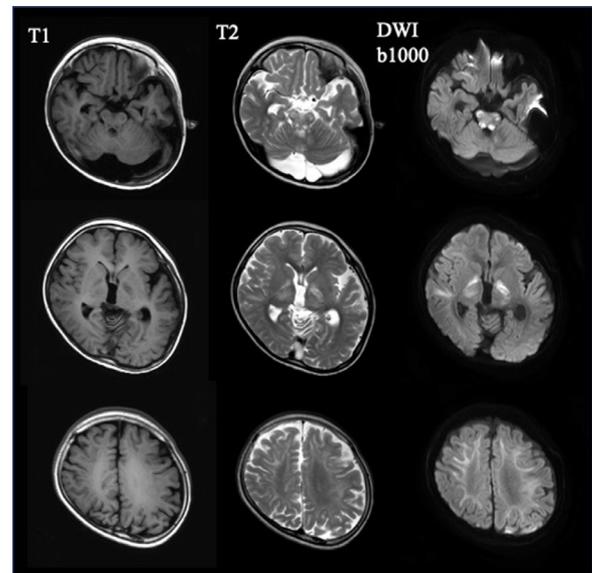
MRI at the age of 7 showed symmetric hypointensity on T1- (left column), and hyperintensity on T2- (middle column) and diffusion-weighted (right column) images in the subcortical white matter, anterior thalamus, globus pallidus, cerebral peduncle, and upper pons.
